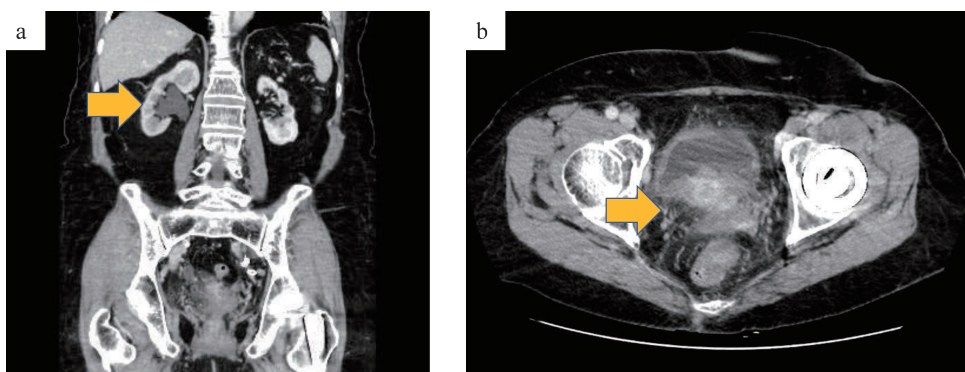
The initial diagnosis by contrast-enhanced computed tomography (CT) scan was cT4aN0M0, stage IIIA
